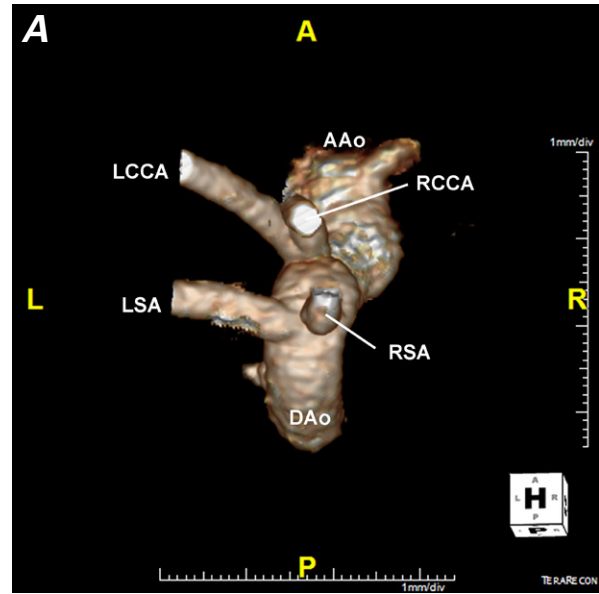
Patient 2. Computed tomogram (volume-rendered 3-dimensional reconstruction). A) View from the head shows the origin of the brachiocephalic vessels and an incomplete vascular ring. B) Posterior view of the origin of the left subclavian artery shows a nondilated proximal portion, excluding the Kommerell diverticulum. Absence of a left-sided ductus arteriosus precludes a vascular ring.
